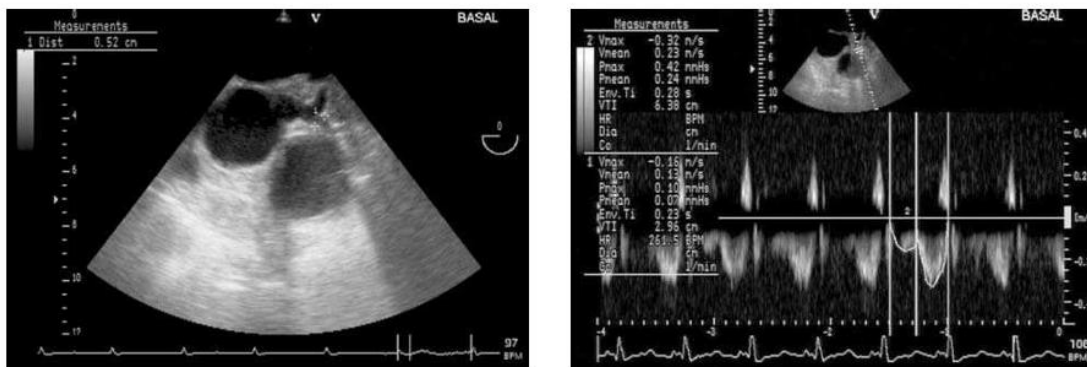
Case number 7 Left coronary system by TEE (2D) and basal Doppler parameters.
